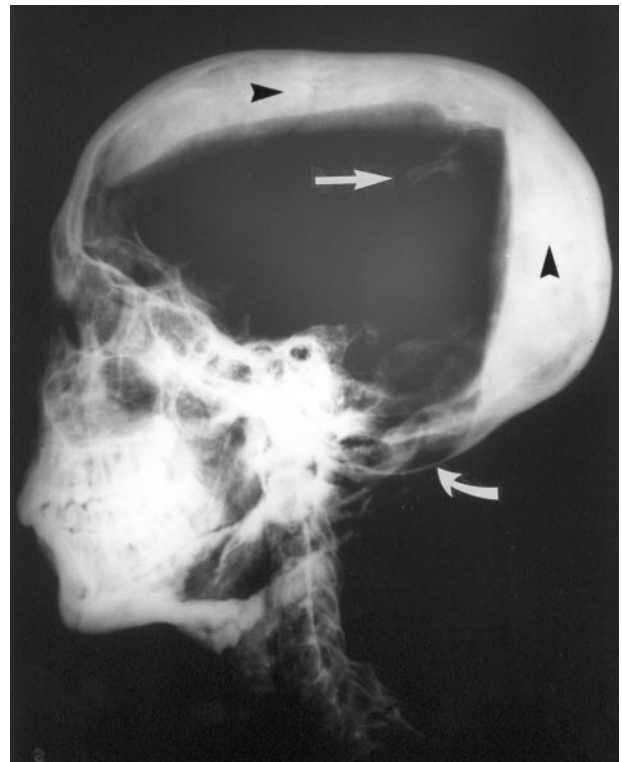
Lateral view radiograph of Tutankhamen's skull and cervical spine. Note the opaque layers of resin in the occipital and vertex regions (arrowheads), the bone fragments (straight arrow) that were probably dislodged during the 1925 autopsy, and the physiological thinning of the floor of the posterior fossa (curved arrow). (Reprinted courtesy of the University of Liverpool.)
